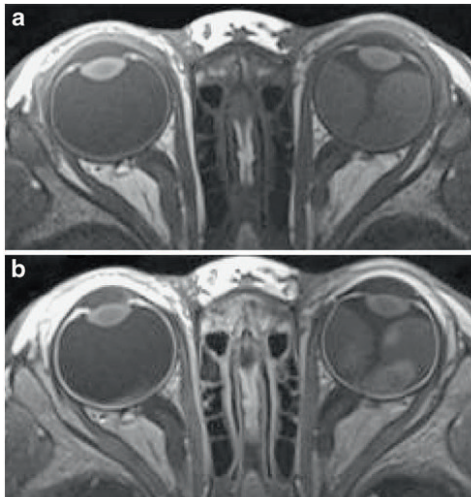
MRI of bilateral retinoblastoma with extensive disease in both eyes should be performed with two surface coils. The field of view should be slightly increased to cover both eyes in the transaxial plane. Imaging example of bilateral lesions: a Precontrast transaxial T1-weighted (TR/TE, 360/13 ms) image. b Postcontrast transaxial T1-weighted (TR/TE, 360/13 ms) image
